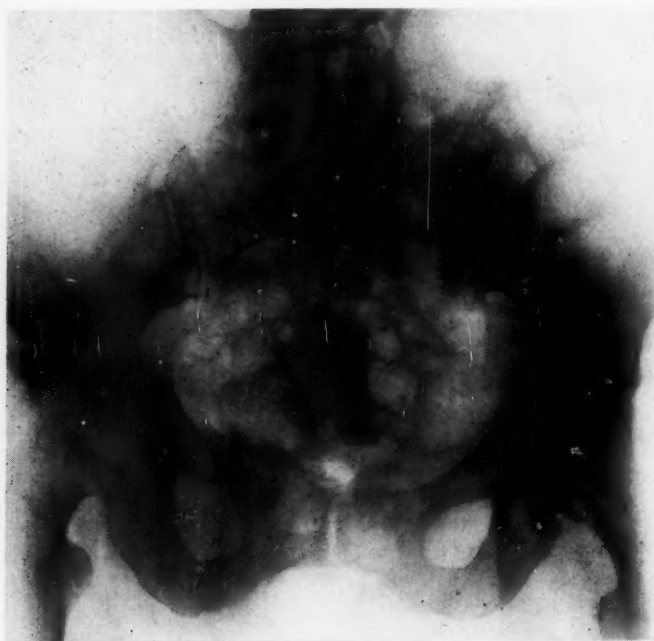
Case 4: Roentgenogram of pelvis, showing pathologic fracture in the region of the acetabulum.
